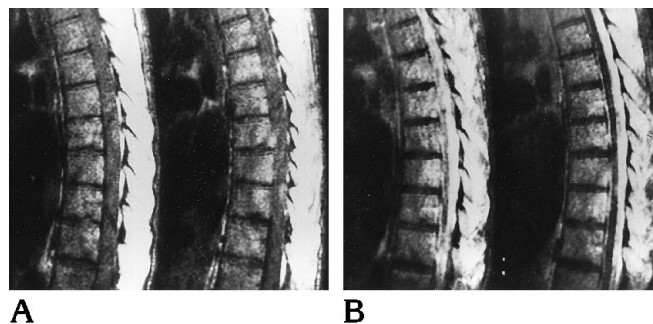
A, Short-repetition-time (550/12) MR image shows poor definition of the intraspinal structures. The cord cannot be identified.
